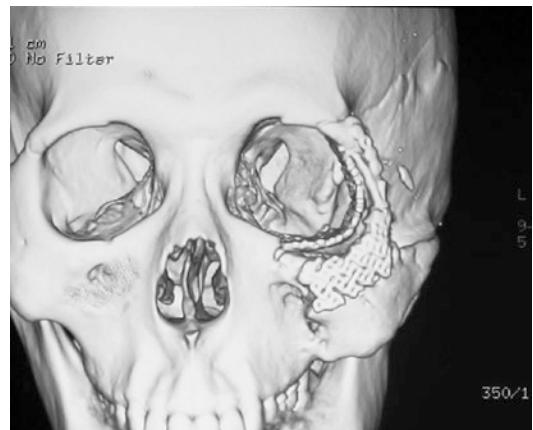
After surgery, three-dimensional reconstruction CT demonstrating titanium mesh implantation, reconstruction of the orbital rim, titanium mesh implantation into the orbit, and reconstruction of the orbital cavity (front view)
